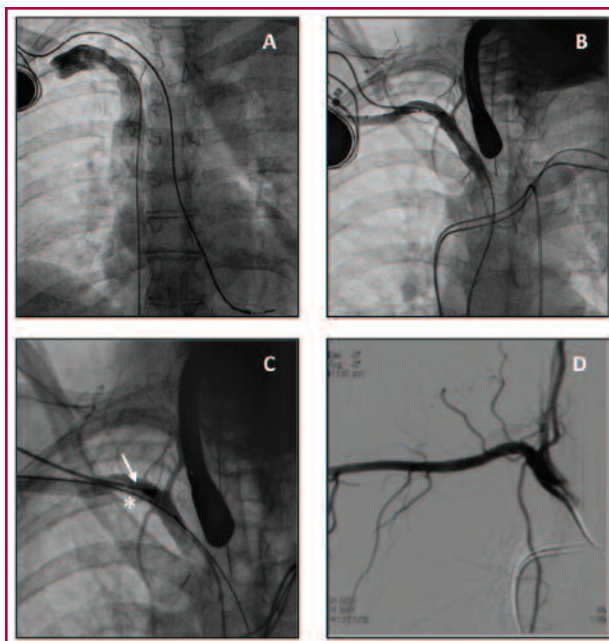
A. Venography of the right subclavian vein showing the pacemaker lead passing outside the vein through the subclavian artery. B. Angiography of the right subclavian artery showing the lead inside the artery, the pigtail catheter, the leads of the new pacemaker and the transesophageal echo probe. C. Covered stent (asterisk) and pacemaker lead (arrow) placed at the entry site to the artery, just before the extraction. D. Digital subtraction angiography showing correct stent deployment without blood extravasation.
